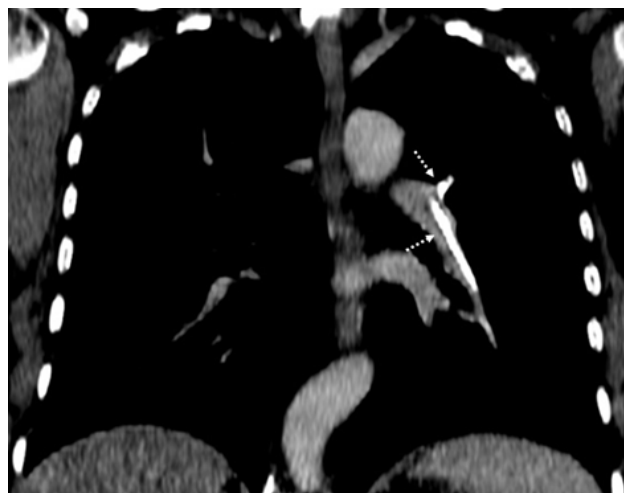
Reconstructed oblique coronal plane venous phase contrast-enhanced CT (mediastinum window) with high attenuating linear intravascular material within the left pulmonary artery and its posterior and descending branches (dashed arrows) consistent with bone cement pulmonary emboli.
